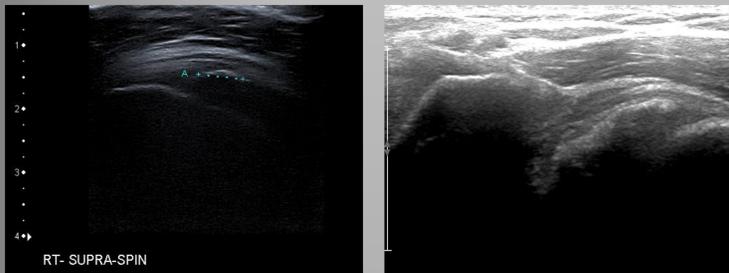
Supraspinatus Cdep on ultrasound(US) demonstrating volume under-estimation of the deposits on x-rays, corresponding to images Fig 1&2
